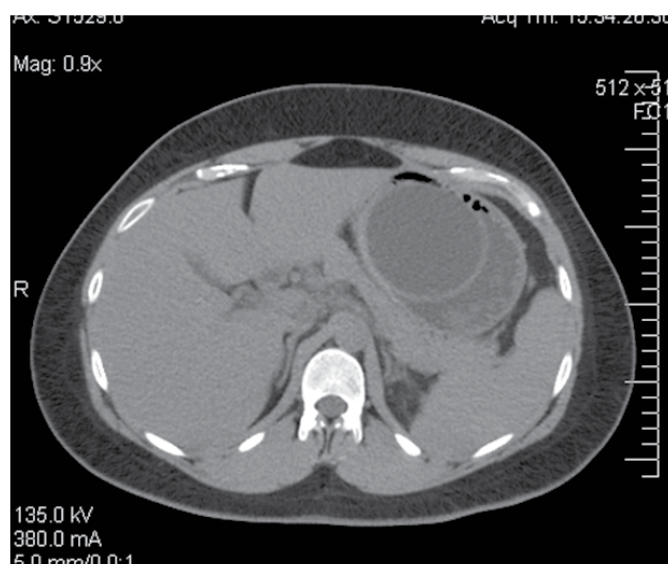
Computed tomography scan of the abdomen showing compression of the pancreas by the intragastric balloon.
